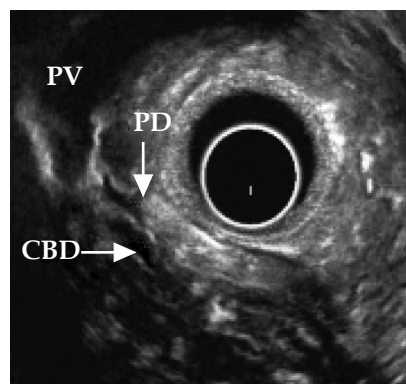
Radial EUS image from the duodenum showing the PD crossing the CBD towards the minor papilla suggesting pancreas divisum (crossed duct sign). CBD: common bile duct; EUS: endoscopic ultrasound; PD: pancreatic duct; PV: portal vein.
